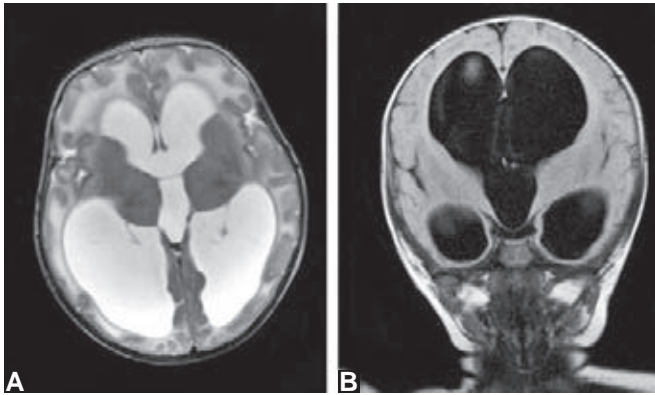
Hydrocephalus. Axial CT scan shows marked dilatation of both lateral ventricles
